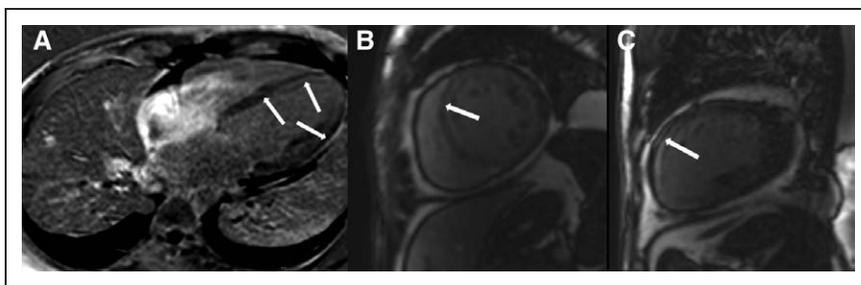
Cardiac magnetic resonance imaging in short-axis (A), 2-chamber (B), and 4-chamber views (C) (gadolinium-enhanced T1 weighted), showing delayed hyperenhancement in the lateral wall and in the septum with a patchy pattern (full white arrows).
